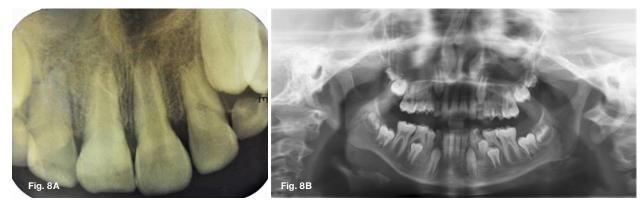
Case 1 - Post treatment radiographs: A. IOPA. B. OPG.
